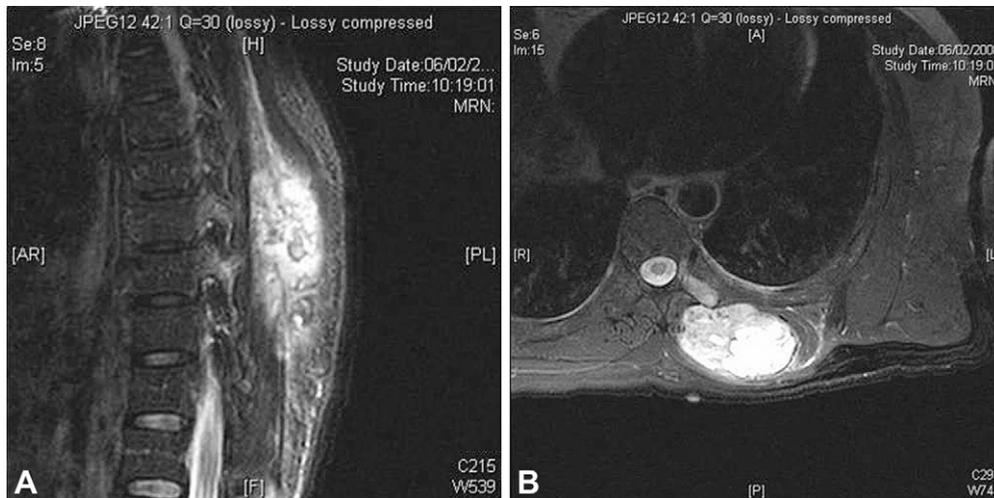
(A) The sagittal and (B) the transverse sections of the magnetic resonance images of the tumour.
